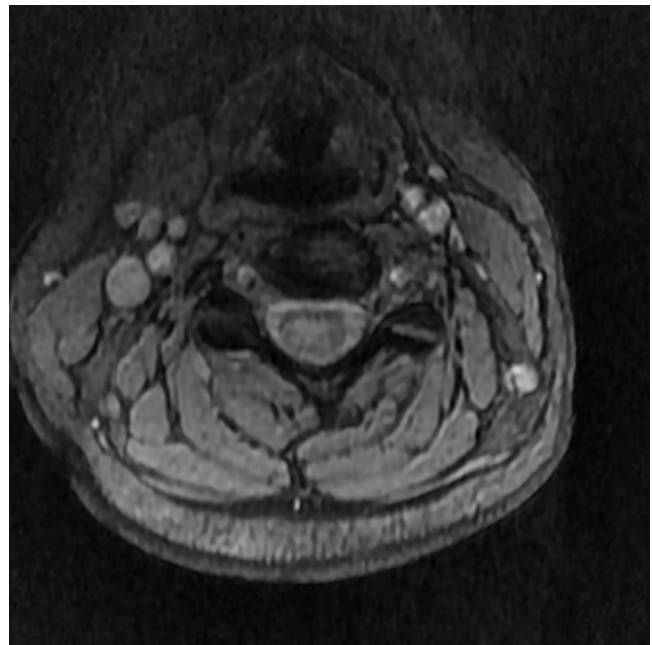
Cervical spinal cord MRI at the C6 level revealed occupied more than half of the spinal cord.
